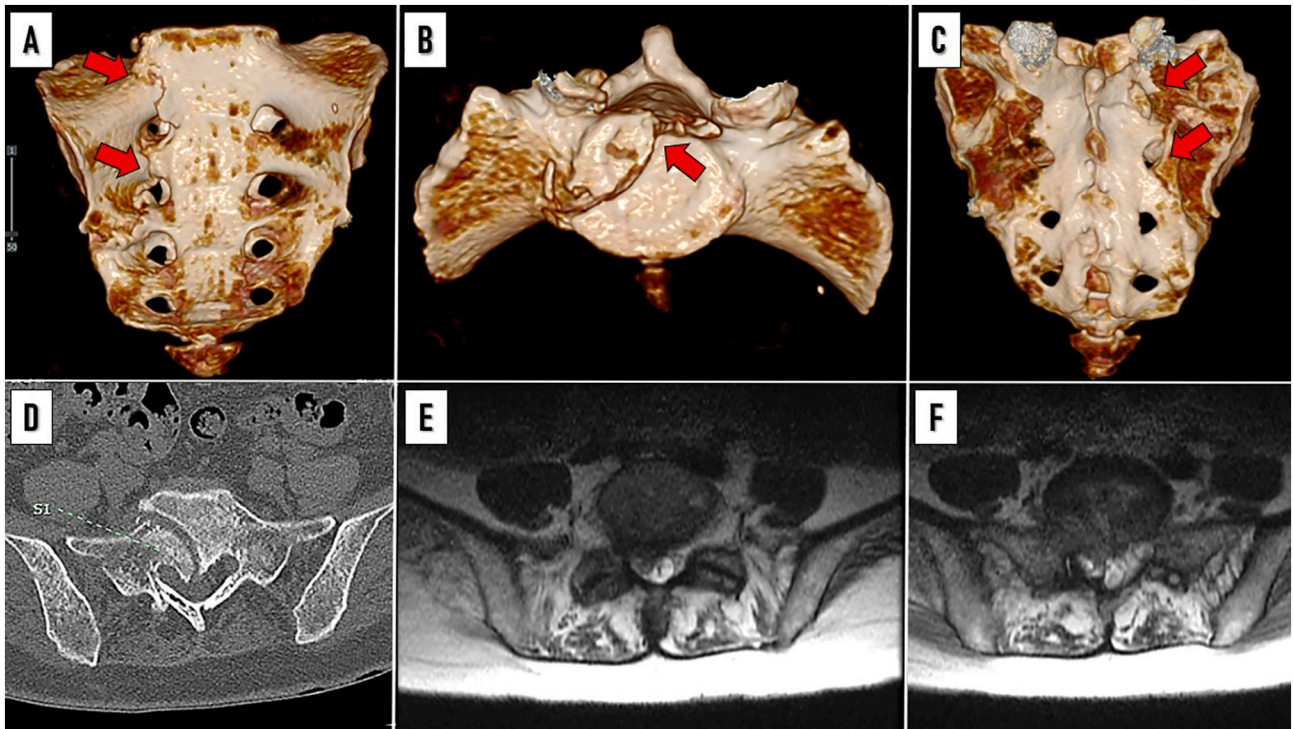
Reconstruction CT scan of sacrum after sacroiliac screw removal. Anterior view (A), Superior view (B), Posterior view (red arrows, C). CT scan of sacrum. Axial view (D). MRI of L5/S1 level (E) and S1 level (F).
